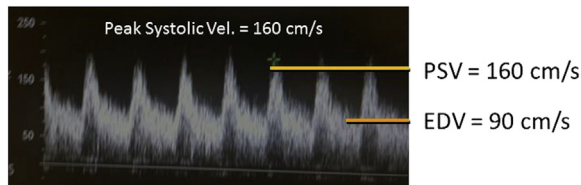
Brachial artery velocity spectral waveform recorded using a 60° Doppler angle and center-stream pulsed-Doppler sample volume location. The value of peak systolic velocity (PSV) and end-diastolic velocity (EDV) are estimated by visual inspection of the waveform. Note the values selected are within, not above, the pulsed Doppler spectral waveform.
